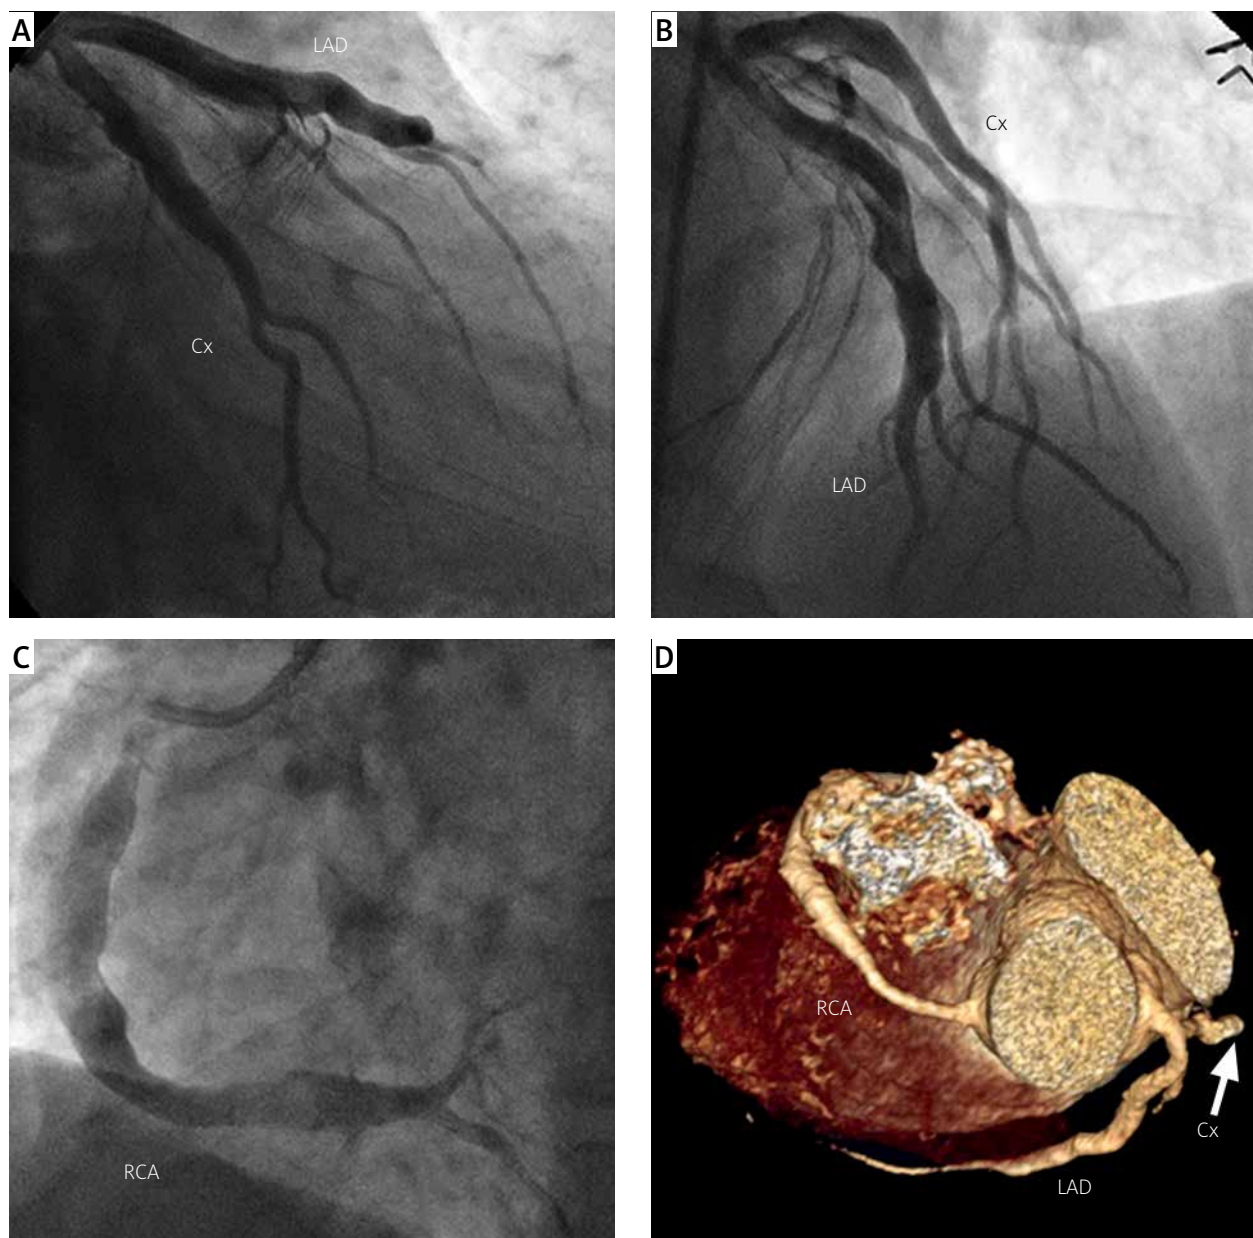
Diffuse coronary artery aneurysms involving the left anterior descending, circumflex (A, B) and right coronary artery (C). Computed tomography angiography confirmed three-vessel involvement (D)
